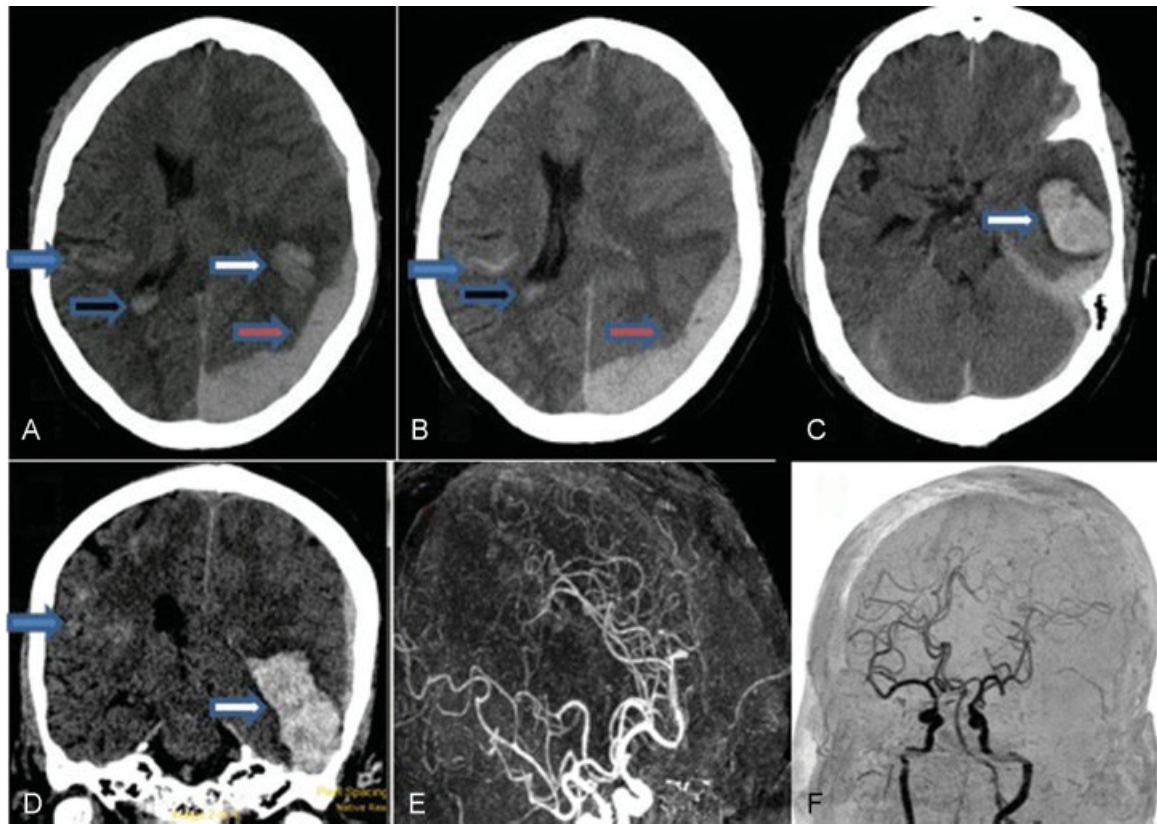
(A–C) CT brain axial view showing subdural/subarachnoid/parenchymal/intraventricular bleeds in bilateral (left > right) temporoparietal region as pointed by different colored arrows. No evidence of fracture (D) in coronal section. (E and F) CT angiogram revealing no abnormality.
